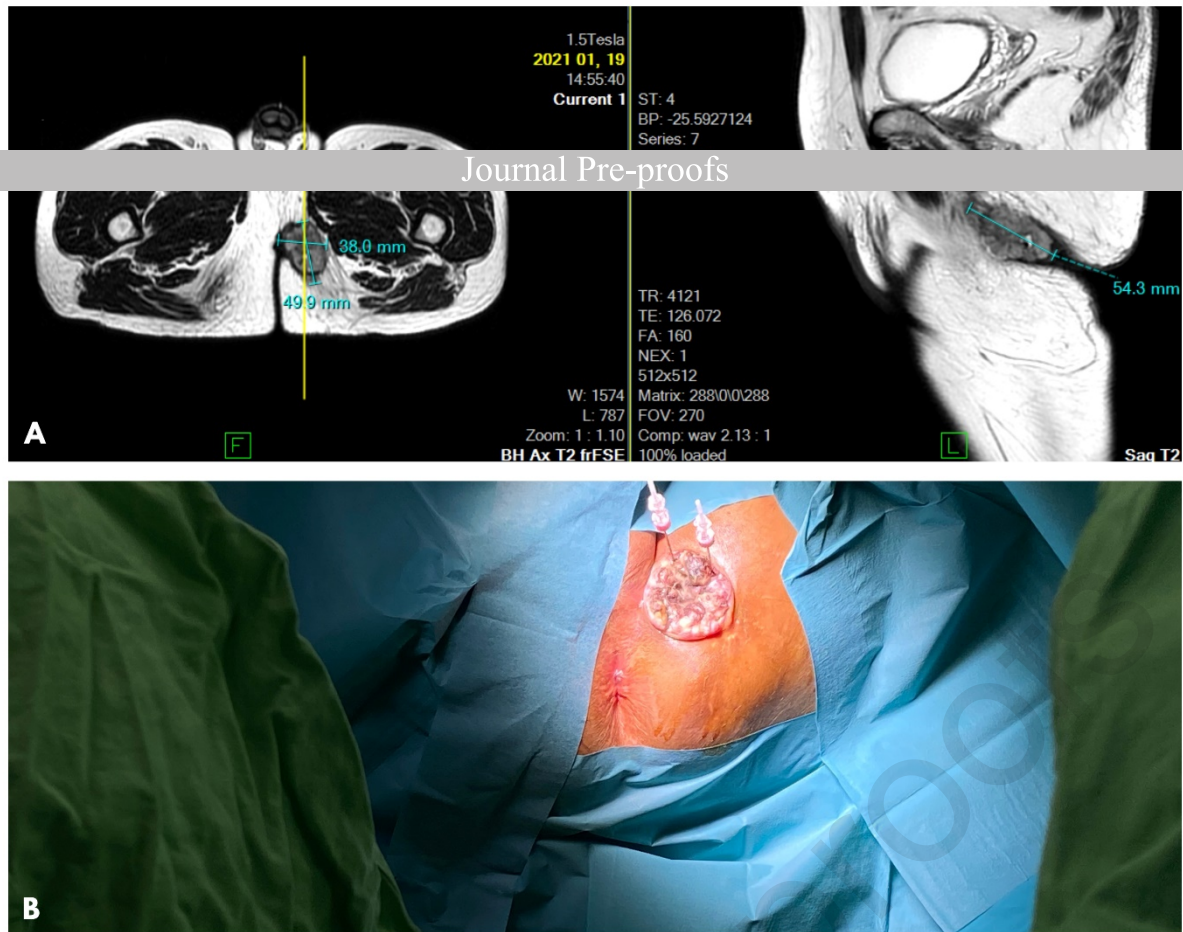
Epithelioid sarcoma of the left gluteal region. A: MRI showing pretreatment extent of the sarcoma. B: Initial electrode placement during VEG ECT treatment. ECT: electrochemotherapy; MRI: magnetic resonance imaging
